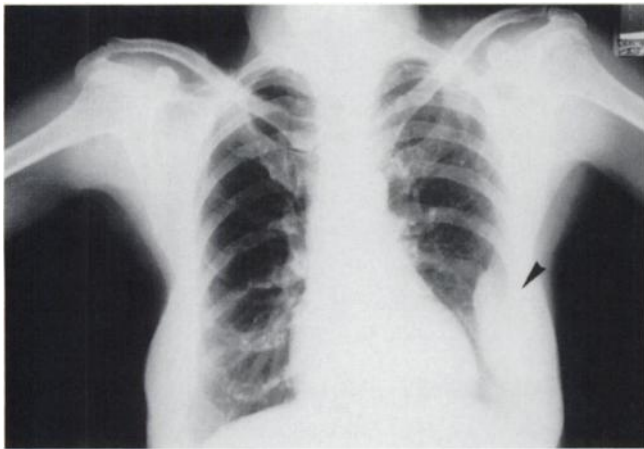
Chest radiograph depicts an abnormality in the left lower hemithorax (arrow). The two foci of faint ^{99m}Tc -tetrofosmin uptake in the lungs were not identified.
